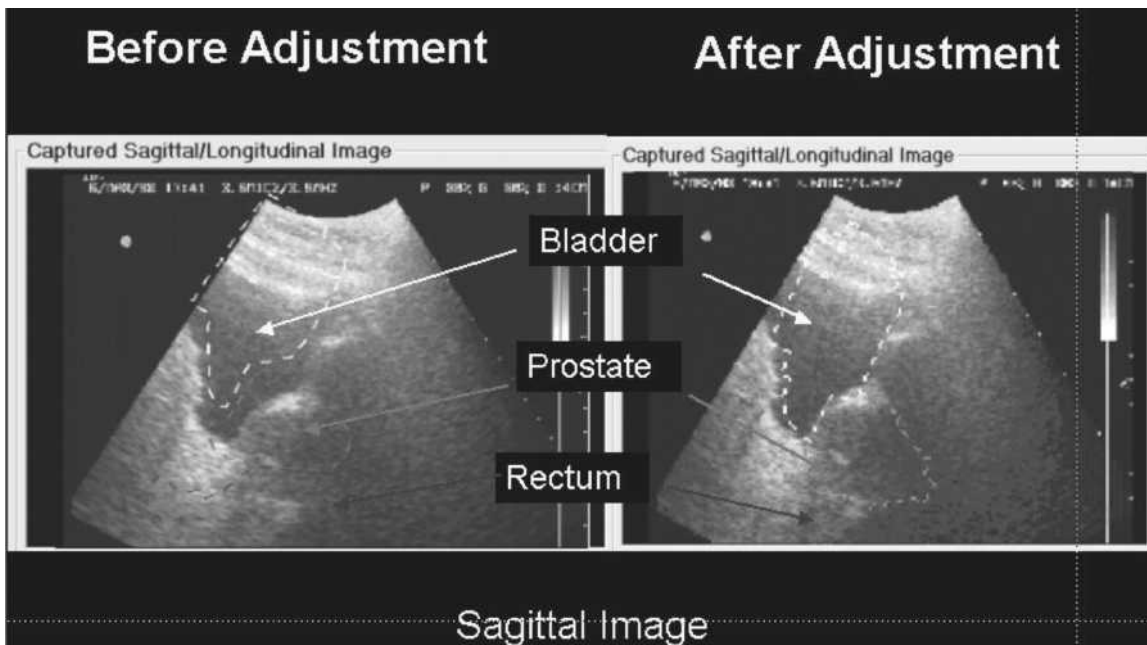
Sagittal ultrasound images of a patient before and after realignment of the patient. (Figure courtesy of Lei Dong, Ph.D., U. T. M. D. Anderson Cancer Center.)
